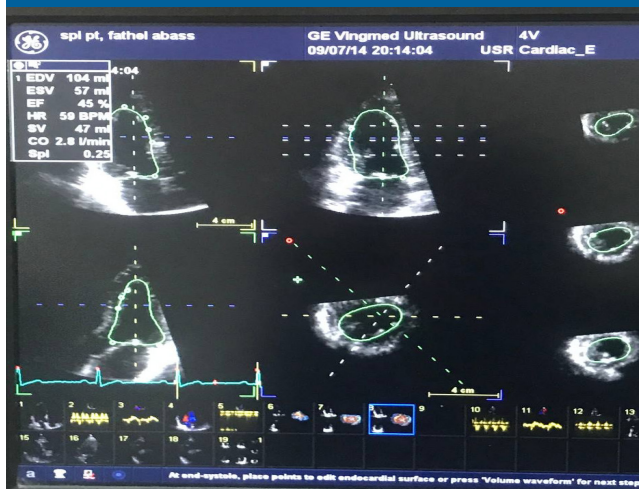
2D –echocardiographic assessment of ejection fraction (EF) and stroke volume (SV).
